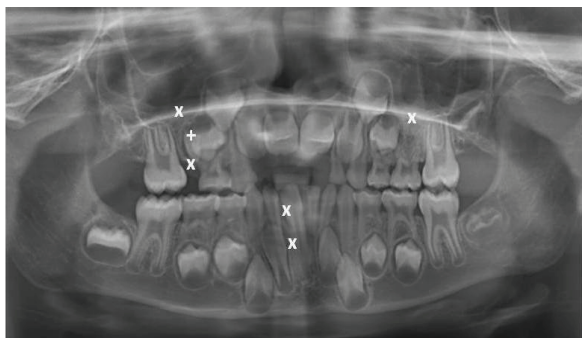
Panoramic radiograph showing agenesis of teeth 15, 55, 25, 81 and 41 (X) and presence of conical shaped supernumerary tooth (+) in premolar region
